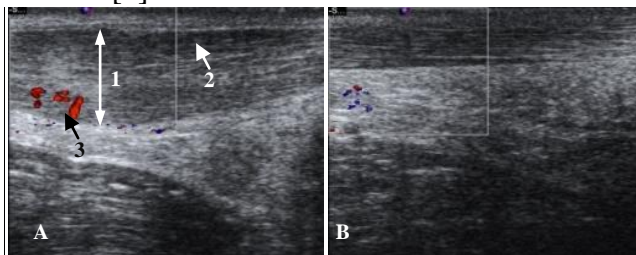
Ultrasound image of the involved Achilles tendon (A). Achilles tendinopathy was characterized by 1) focal thickening of the tendon; 2) hypoechoic region; and 3) neovascularization compared to uninjured tendon (B).
